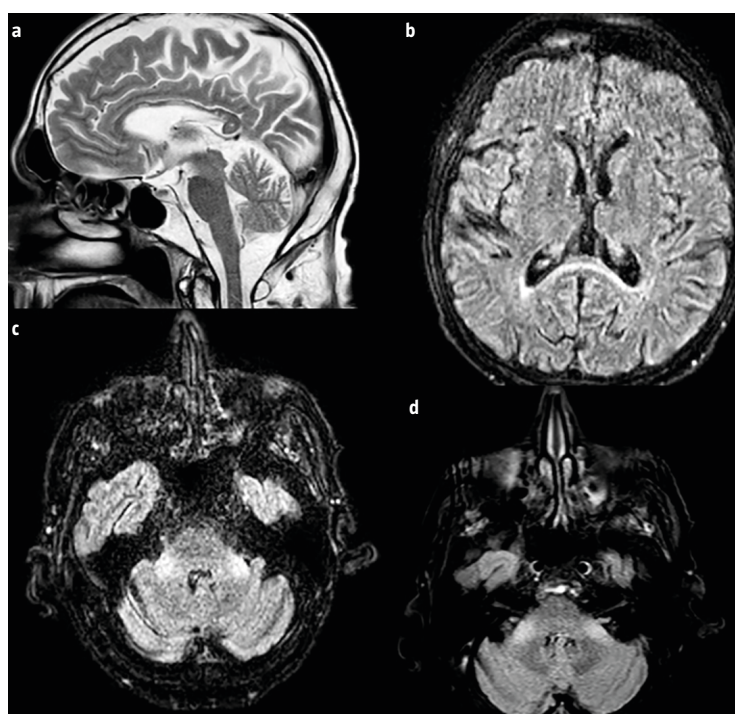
a) In T₂WI magnetic resonance image, we can see hyperintensity at the splenium of the corpus callosum in sagittal sequences. b) In T₂-FLAIR we also observed hyperintensity at the splenium of the *corpus callosum* in axial sequences. c) In axial DWI sequences, we appreciated hyperintensities in bilateral middle cerebellar peduncles, also known as MCP-sign. d) In T₂-FLAIR we also observed the MCP-sign.
